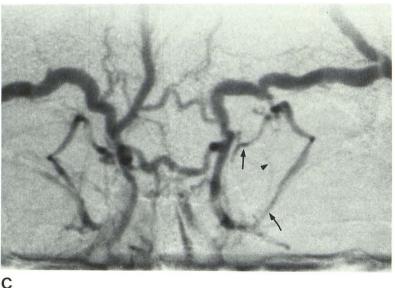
A and B, Bilateral internal carotid magnification arteriography. Marked elongation and stretching of left ophthalmic artery and branches (arrow). Normal right artery head). C, Frontal venogram. Left superior ophthalmic vein shows narrowing of P1 (top arrow) and P3 (bottom arrow). Loss of definition and lateral displacement of left median connecting vein (arrowhead). Unremarkable right superior ophthalmic vein. CT was abnormal with proptosis, uveoscleral thickening, and an enhancing density in the left orbital apex. The patient improved with steroid therapy and no surgery was performed.
